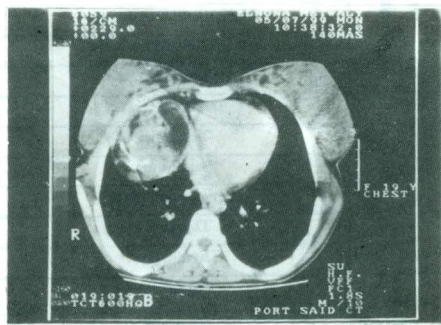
CT scan of the same case in fig 5.
